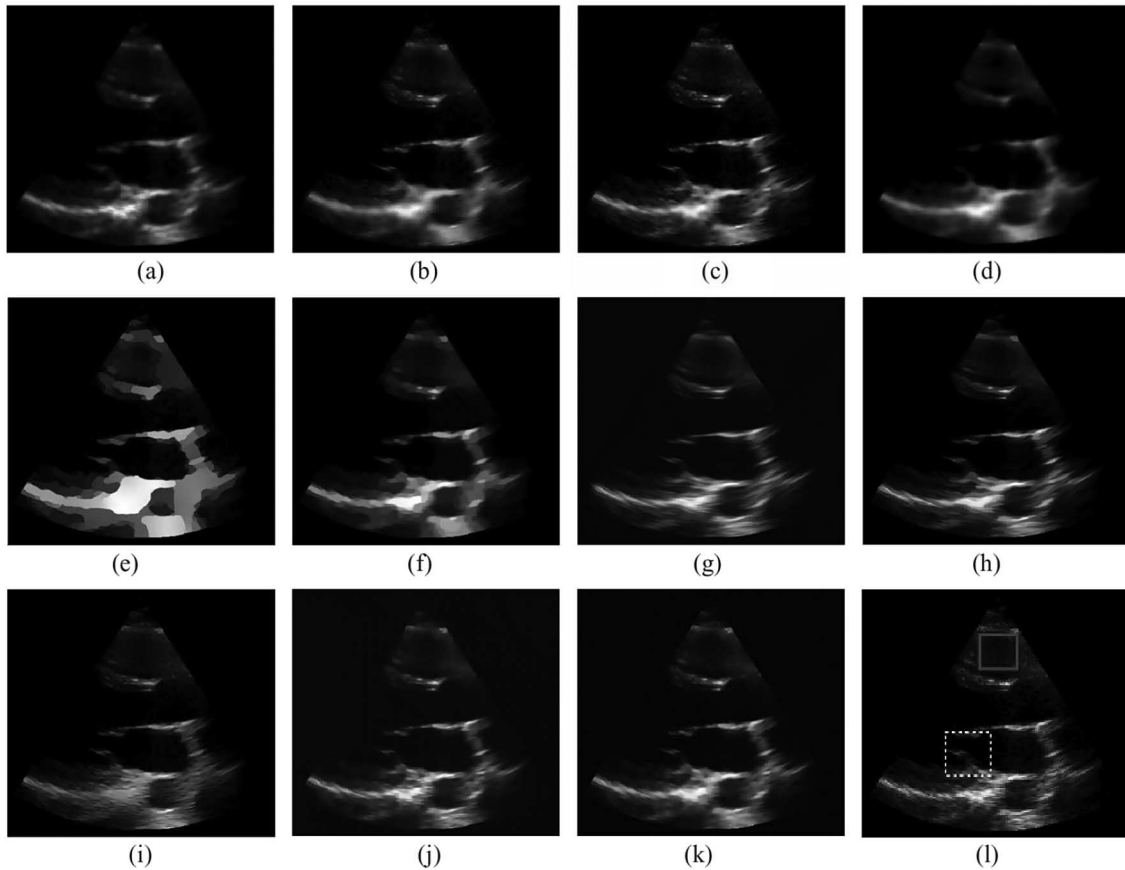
Effect of a range of filtering techniques on a log-compressed frame from a clinical transthoracic parasternal long-axis echocardiographic video. Adaptive local statistics filters: (a) Lee *et al.* [32], (b) Kuan *et al.* [34], and (c) Frost *et al.* [33], [35]. Anisotropic diffusion filters: (d) Perona and Malik diffusion (PAMD) [58]. (e) SRAD [59], (f) detail preserving anisotropic diffusion (DPAD) [60], (g) nonlinear coherent diffusion (NCD) [61], and (h) OSRAD [62]. Wavelet filters: (i) Zong *et al.* [53], (j) generalized likelihood method (GML) [48], and (k) NMWD filter [63], integrating wavelet transforms with anisotropic diffusion. (l) Original, unprocessed frame with the RV and mitral-valve regions highlighted (used in the original study for CNR estimation). The figure has been adapted with relevant permission from [64].
